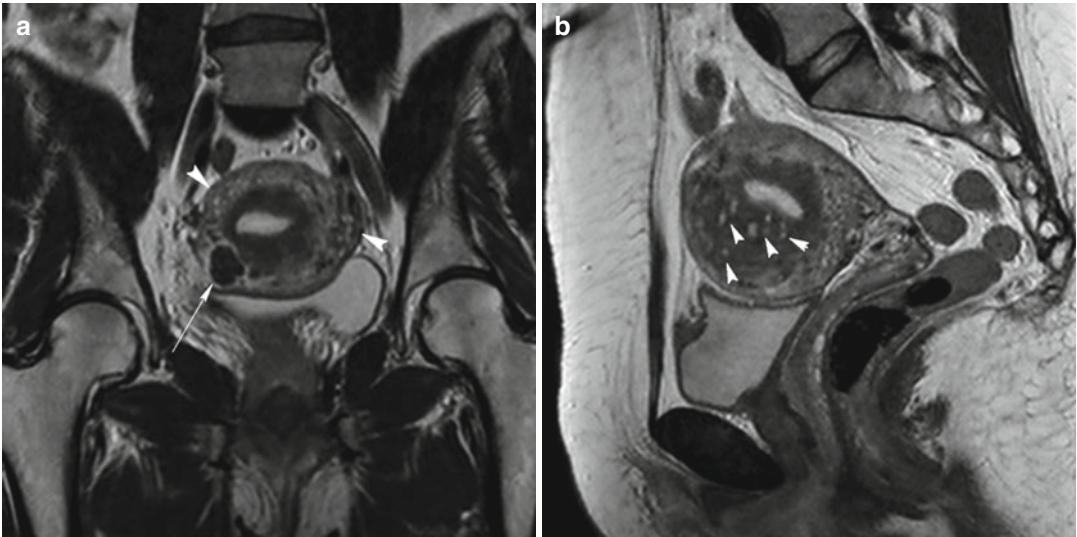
Diffuse adenomyosis coexists with intramural leiomyoma. Coronal (TR 3,700 ms, TE 100 ms) (a) and sagittal (TR 3,250 ms, TE 80 ms) (b) T2-weighted images show several punctate foci of high signal intensity (*arrowheads*)
